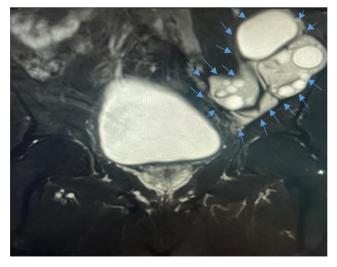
Multiloculated septal cystic mass in the iliac muscle on coronal section T2-A MRI (little blue arrows) *MRI: Magnetic resonance imaging*
